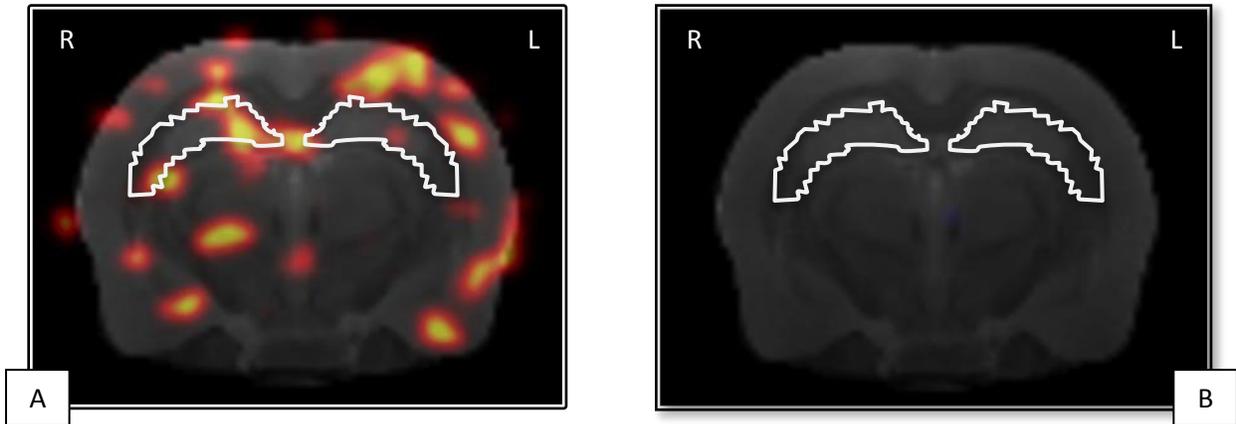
PET-FDG image of the hippocampus.
